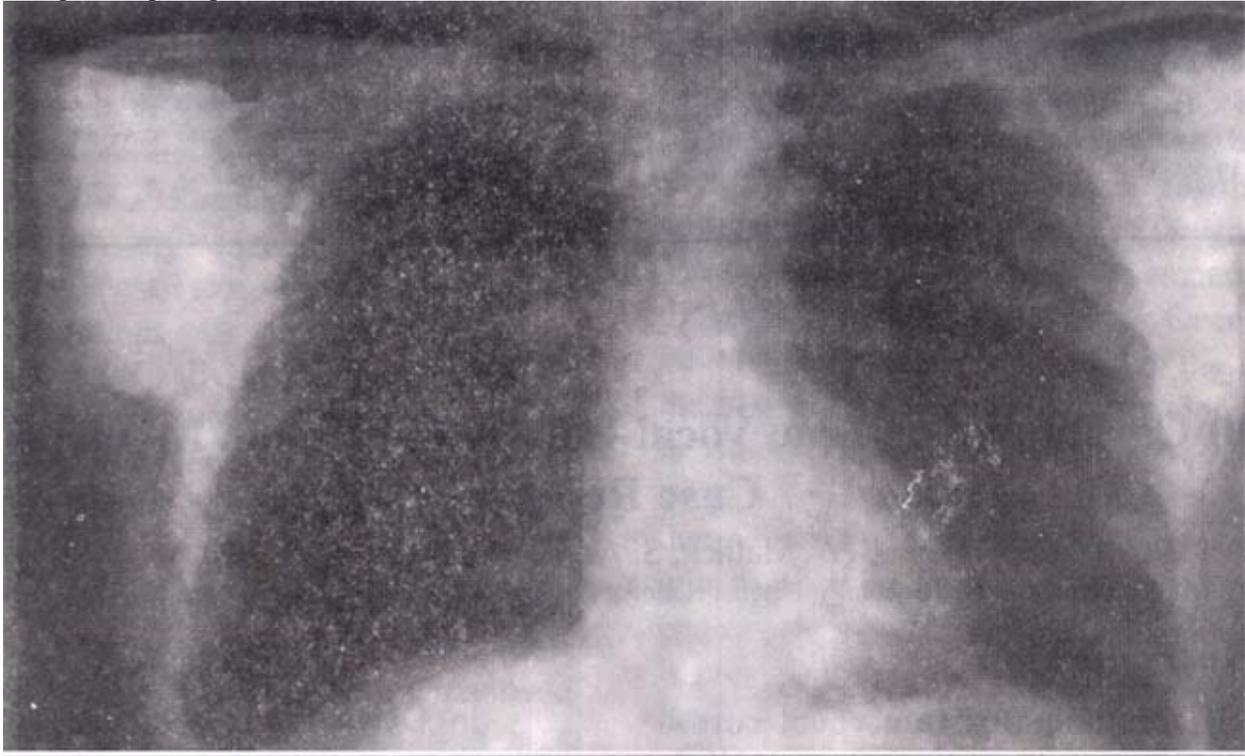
X-ray chest showing multiple well defined opacities with cavitation in right upper lobe.
